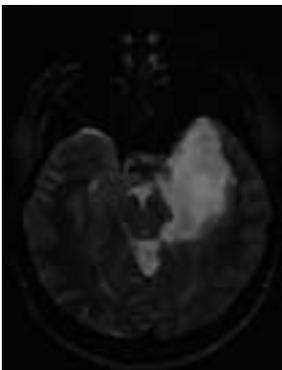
T2-weighted MRI obtained prior to surgery, showing oedema of brain tissue in the left temporal region.
